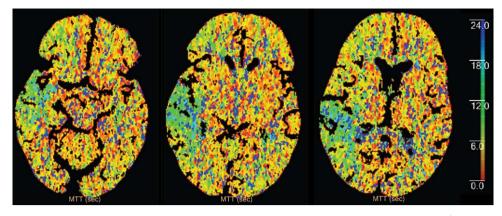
CT perfusion maps showing prolonged mean transit time with tissue at risk throughout the greater part of the right middle cerebral artery territory.
